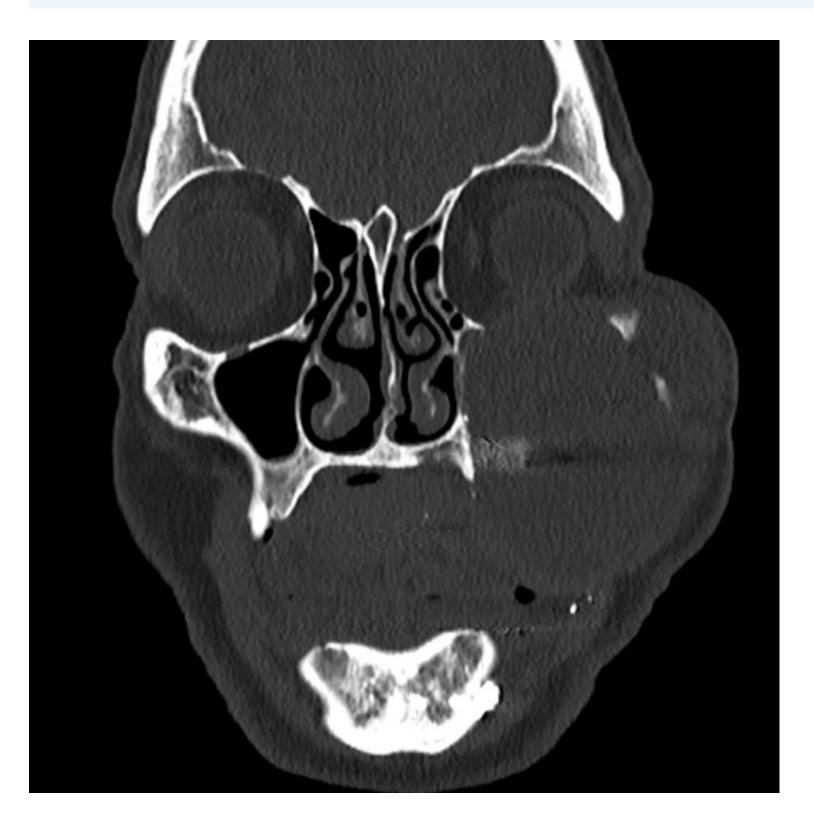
CT, Bone Window, Coronal - Left orbital floor destruction with absent malar prominence
